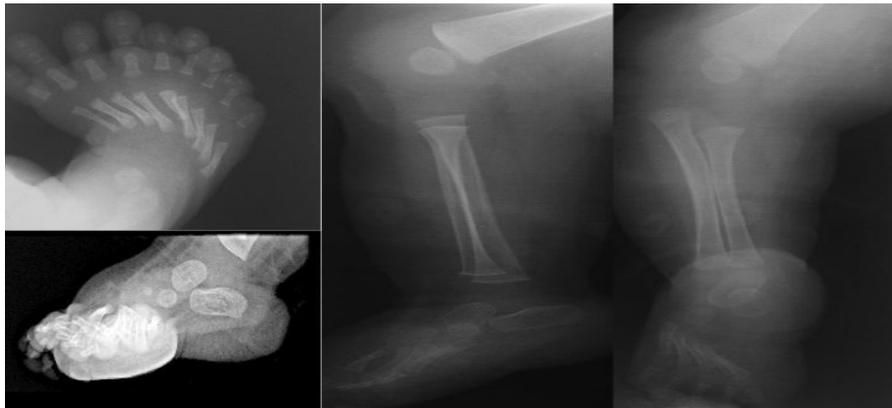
Radiographic views of fibular dimelia and duplication of foot.
